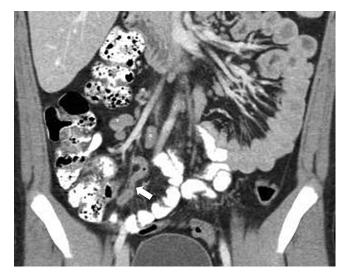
Coronal image from a CT scan with intravenous and enteric contrast in a pediatric patient with right lower quadrant pain shows multiple enlarged right lower quadrant mesenteric lymph nodes (*asterisk*). Note the normal appendix (*arrow*).
